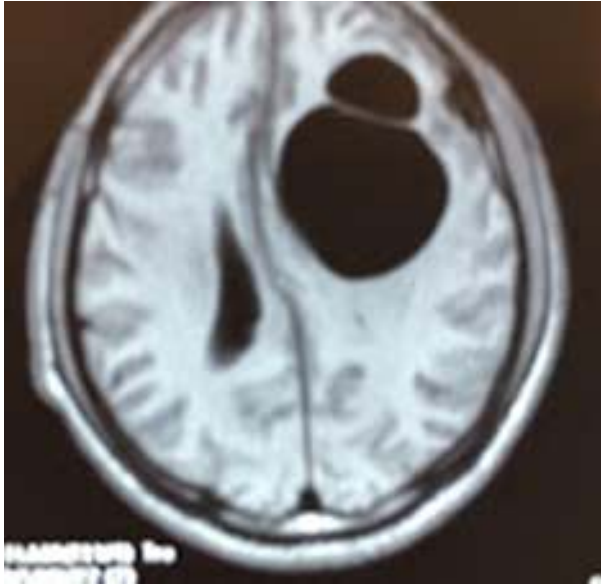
Magnetic resonance Image (MRI) showing a bi-lobed cystic lesion in the left frontal region with significant midline shift.
